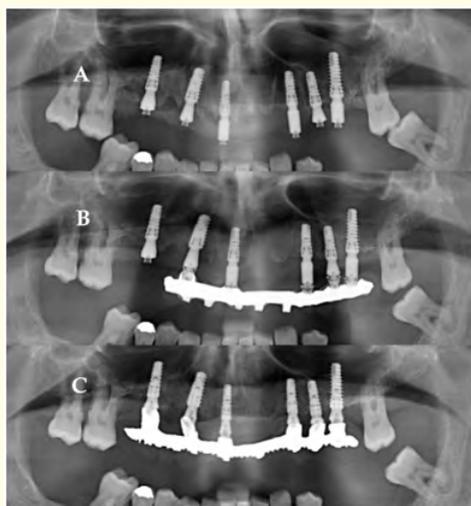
Post-operative panoramic X-rays showing: A: Immediate implant placement, B: Immediate loading with a temporary OT Seeger bridge, and C: Final loading with the permanent OT Seeger bridge.
